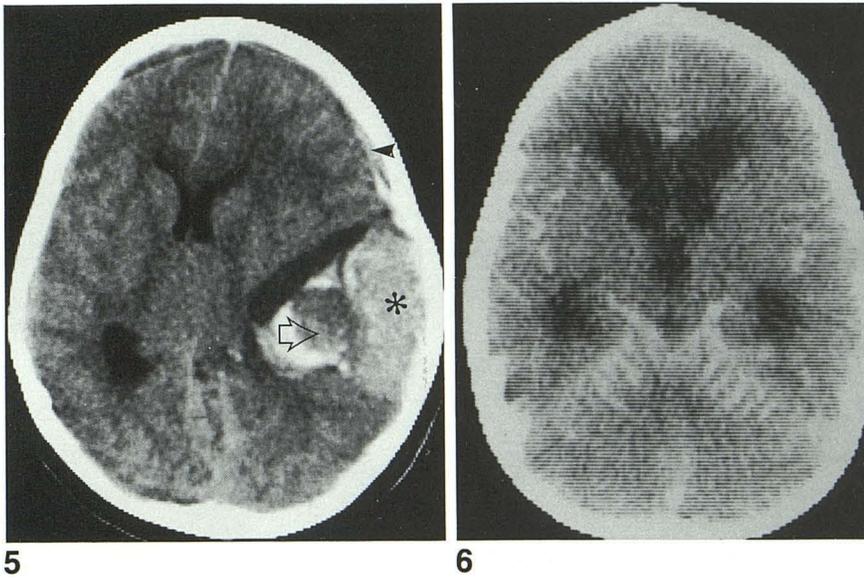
Unenhanced axial CT. Malignant melanoma (case 20), showing hyperdense mass (*asterisk*) with proven diffuse components spreading anteriorly (*arrowhead*) and with underlying focus of partially clotted hemorrhage (*open arrow*) responsible for child's acute presentation (nonenhanced scan only done at time of presentation).
